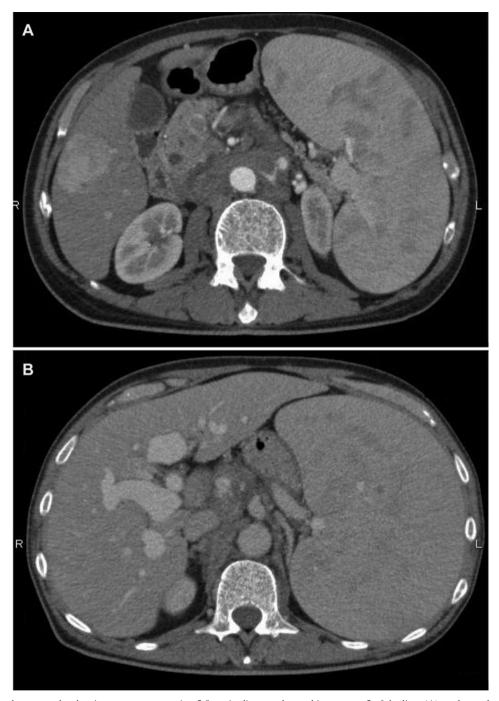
Computed tomography showing a tumor measuring 5.0 cm in diameter located in segment 5 of the liver (A), and portal vein dilatation and splenomegaly (B).
